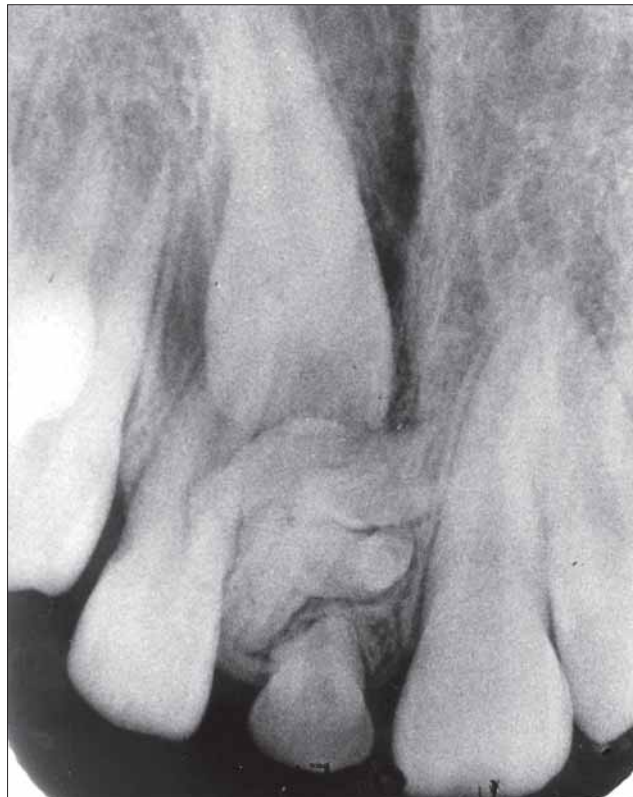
Case 3. Periapical radiograph showing the presence of a compound odontoma blocking the eruption of the permanent upper right central incisor.
